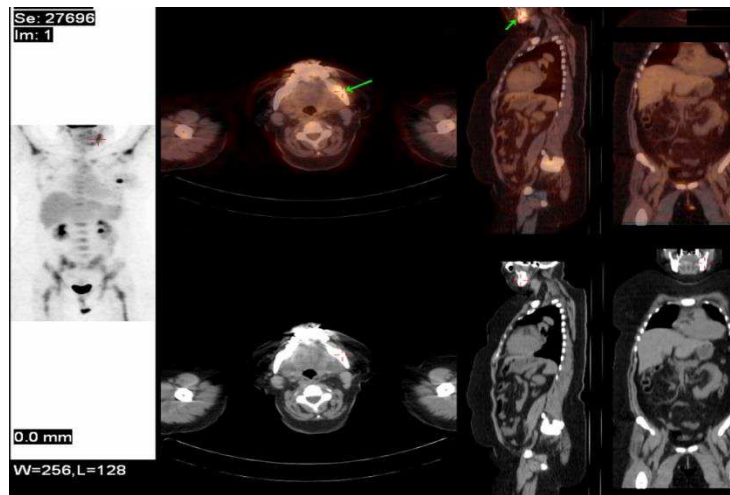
Distribution of radionuclide  $^{18}\text{F}$  in the patient's body (according to PET-CT data, it can be seen that the radionuclide has spread along the lower jaw)
